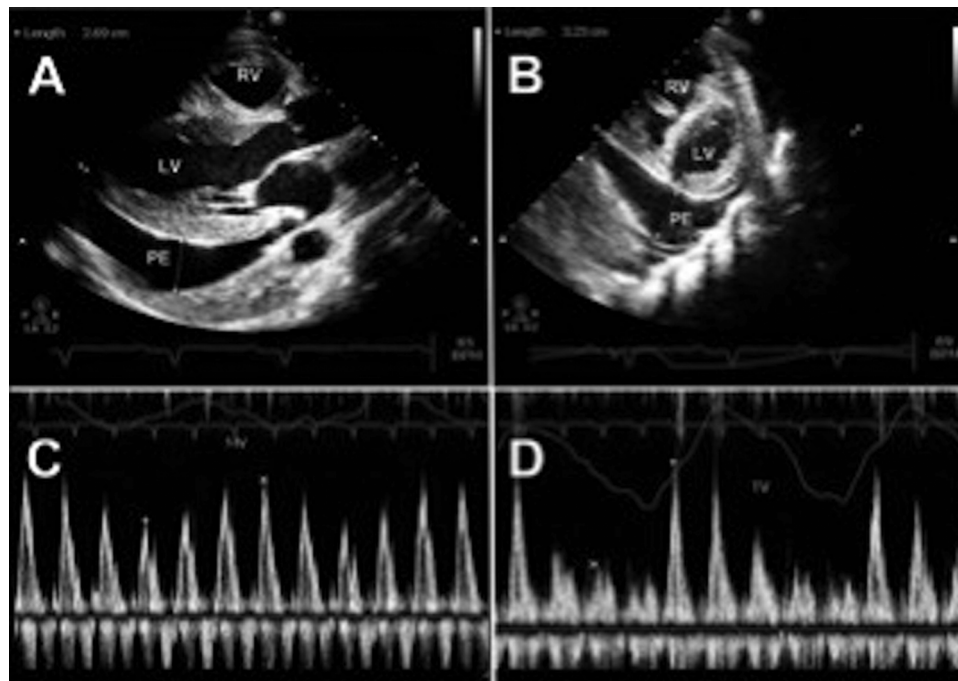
Pericardial tamponade in a patient with heritable pulmonary arterial hypertension. A, Parasternal long axis view showing pericardial effusion measured at 2.7 cm. B, Parasternal short axis view revealing a large pericardial effusion measured at 3.2 cm and a mildly dilated right ventricle (RV). C and D show mitral and tricuspid Doppler flow, respectively, with marked respiratory variation (62% across the tricuspid valve and 36% across the mitral valve). LV: left ventricle; MV: mitral valve; PE: pericardial effusion; TV: tricuspid valve.
